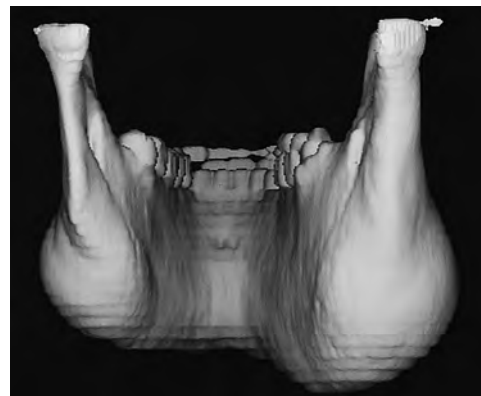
The lateral and inferior views of the three-dimensional reconstruction of the computed tomography scan of the patient shown in Figs. 16.9 through 16.11 showing the expansile lesion (arrow).
